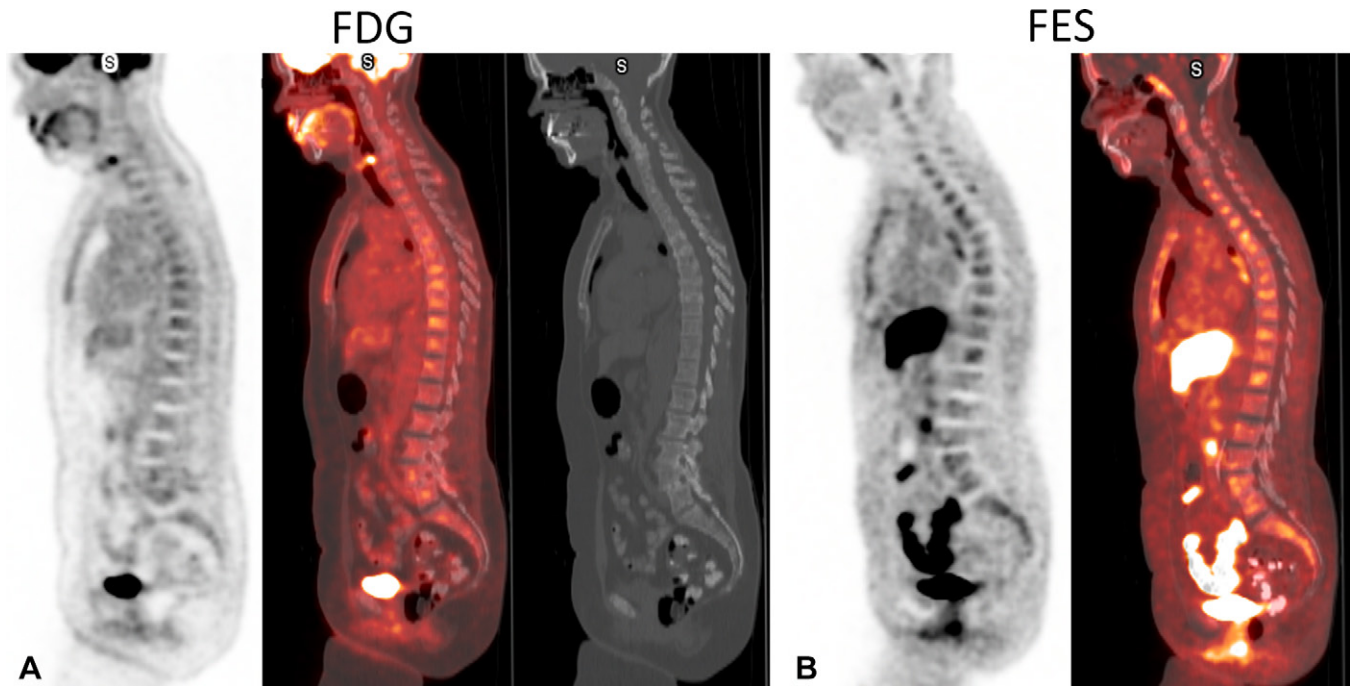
Metastatic ER-positive invasive lobular carcinoma with biopsy-proven ER-positive nodal metastasis and presumed ER-positive osseous metastases in a 66-year-old woman. (A) Sagittal FDG PET (left) and fused FDG PET/CT (middle) images show mild FDG uptake throughout the bone marrow, only slightly above that of blood pool, which could be marrow disease or reactive marrow. Sagittal CT image (right) shows subtle but diffuse lytic and sclerotic changes suggestive of metastasis (SUV scale, 0–4.6). (B) Sagittal FES PET (left) and fused FES PET/CT (right) images show clearly abnormal FES uptake in the bones, which is highly suspicious for functionally ER-positive metastasis (SUV scale, 0–3). Years of clinical and imaging follow-up demonstrated widespread sclerotic osseous metastasis.
